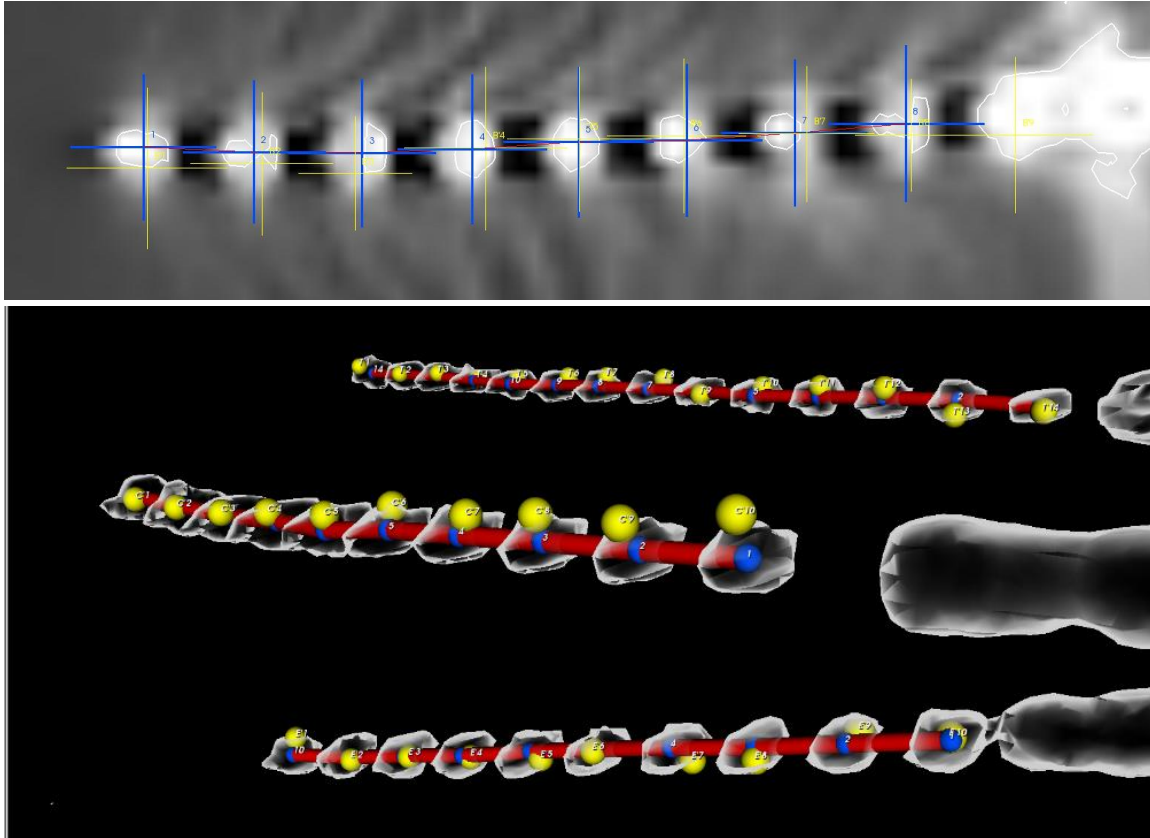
Comparison of the automatic (blue crosses and spheres) and manual (yellow crosses spheres) contact segmentation of SEEG electrodes from a postoperative CT scan.
